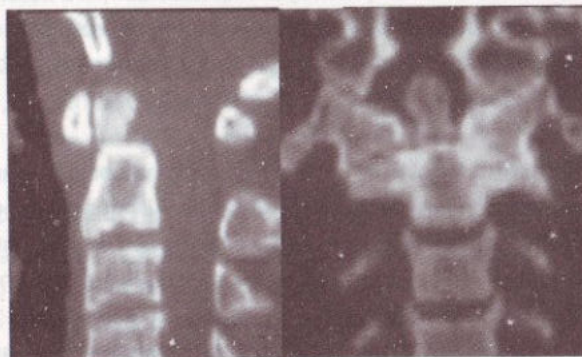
CT scan sagittal and coronal reconstruction showing type-II odontoid fracture
